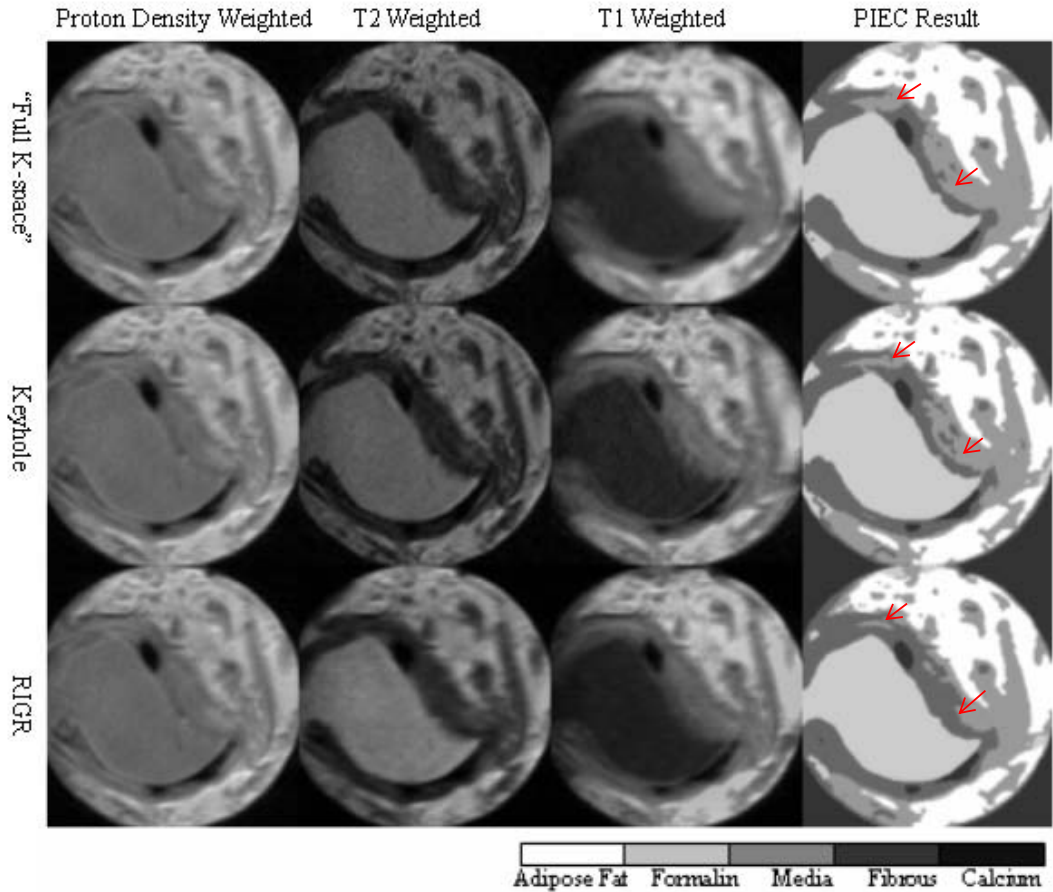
MAGIC-FCM was used in PIEC to perform the segmentation because of the inhomogeneity residing in the MR images. It is shown in this example that MAGIC procedure helps remove the inhomogeneity (arrows) prior to classification.
